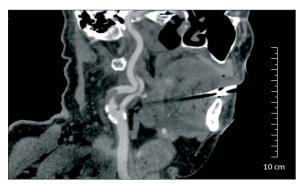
CT angiogram Figure shows left common, internal, and external carotid arteries, with calcification (white) in terminal left common carotid artery, and calcification (white) and thrombus (black) causing very severe stenosis at origin of left internal carotid artery.
